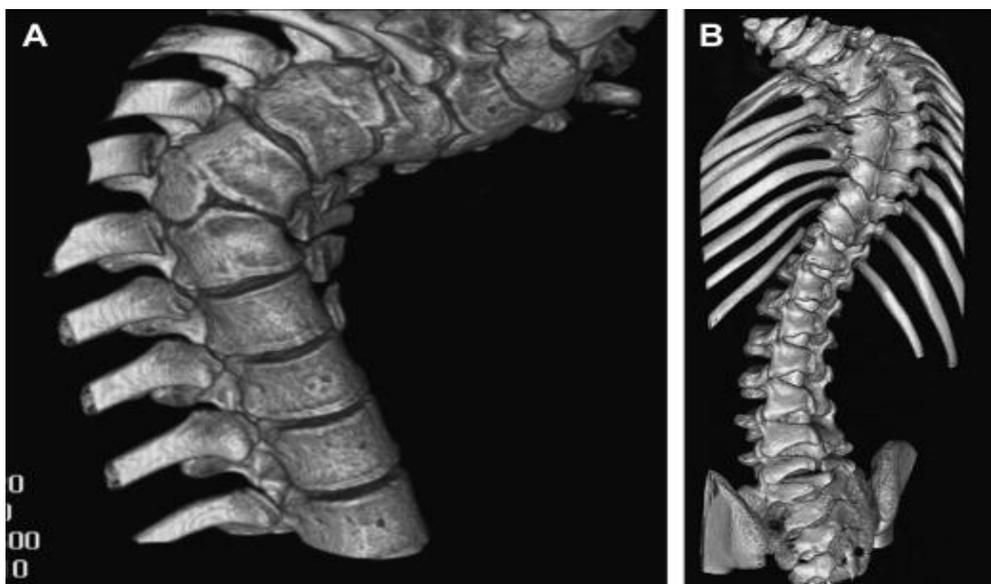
Three-dimensional reconstructions of computed tomography scans of 2 different patients with congenital scoliosis. (A) There is a failure of formation with a hemivertebrae visualized at the apex of deformity. (B) There is a failure of segmentation with unilateral bar and fused ribs at the apex of deformity
